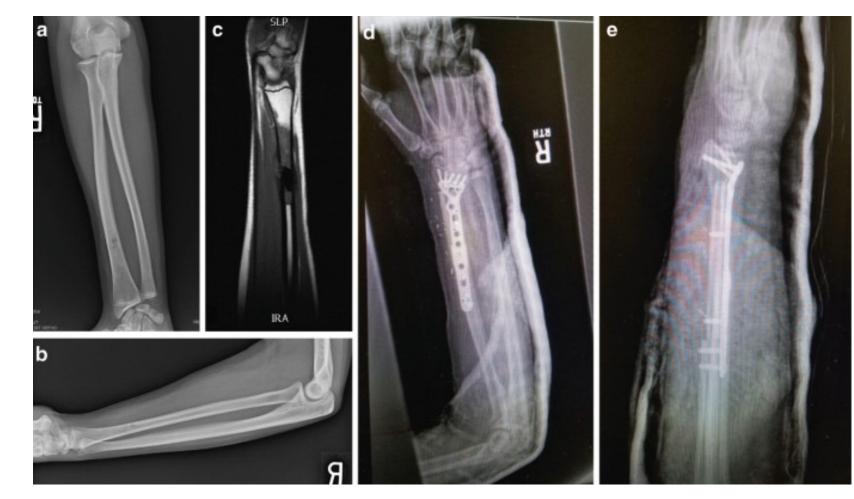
(a, b) X-ray shows an osteosarcoma-related lesion located at the distal radius. (c) The extent of tumour is depicted by an MRI scan. (d, e) Postoperative radiographs show successful reconstruction of the region using a vascularized fibular graft [15].
